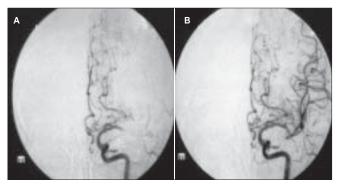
A 61-year-old right-handed man experienced sudden-onset right hemiplegia and muteness of 3.5 h duration. NIHSS was 22. Head CT scan was normal. Cerebral angiography showed complete occlusion of the proximal left MCA (panel A). The patient received IA UK with complete recanalization of the left MCA (panel B) and resolution of his neurological deficits
